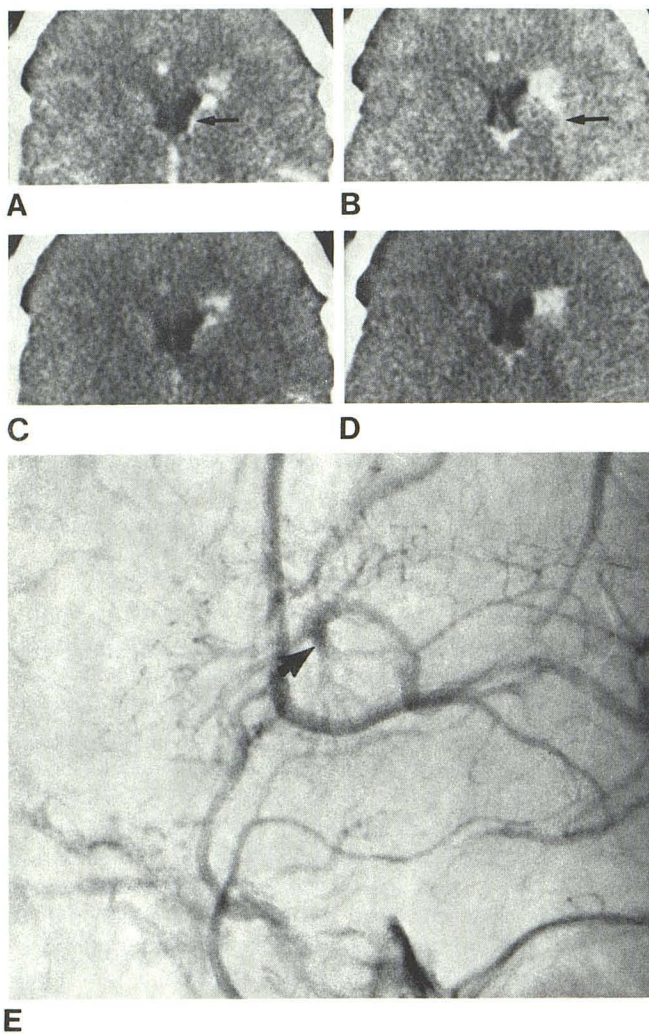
Category 3 lesion. A and B, Immediate contrast CT. High density lesion anterior to the head of caudate nucleus with linear densities extending from it (*arrows*). C and D, Delayed high dose contrast scan, same window settings. Fading linear densities with continued detection of lesion. E, Lateral carotid angiogram, venous phase. Lesion with extending vessels (*arrows*). Venous angioma was found at surgery adjacent to left frontal horn.
